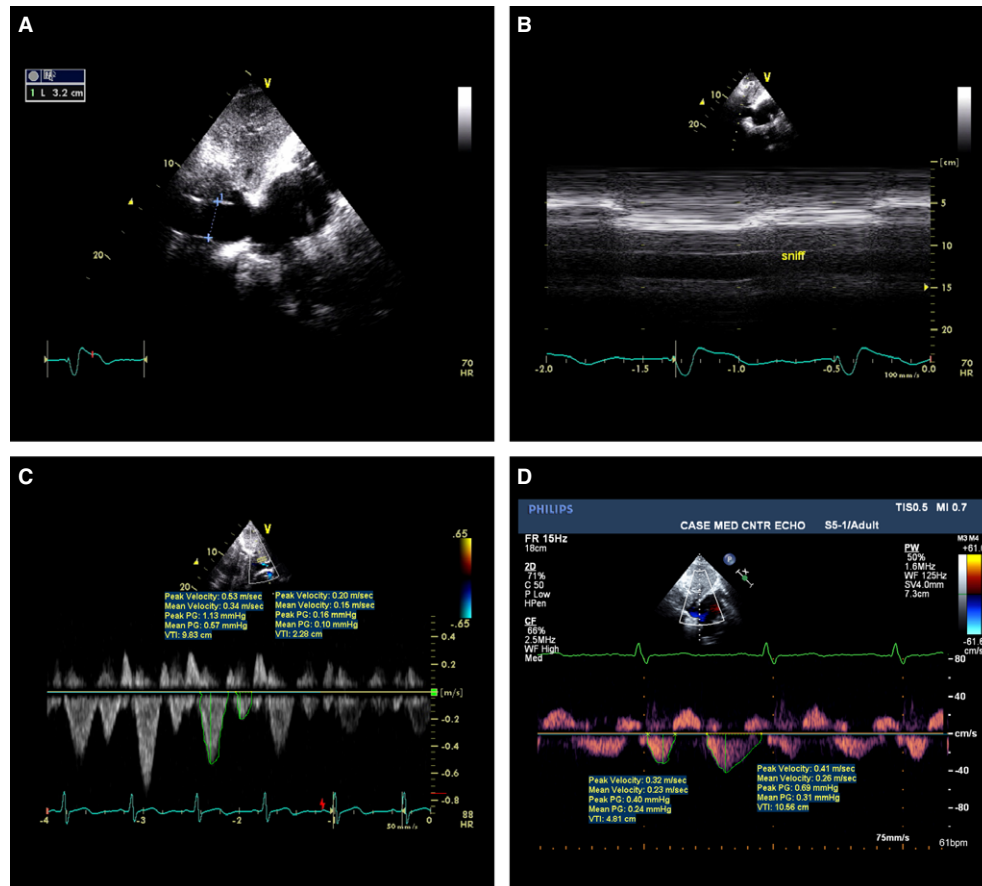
RA pressure estimates from the IVC size and the pattern of hepatic vein flow. Elevated RA pressure evident from a two-dimensional echocardiogram of a markedly dilated IVC A, and an M-mode echocardiogram of the IVC before and during a sniff B, spectral Doppler of hepatic venous flow demonstrating greater systolic than diastolic flow, indicative of normal RA pressure C, spectral Doppler of hepatic venous flow demonstrating greater diastolic than systolic flow, indicative of elevated RA pressure D. RA = right atrial; IVC = inferior vena cava.
